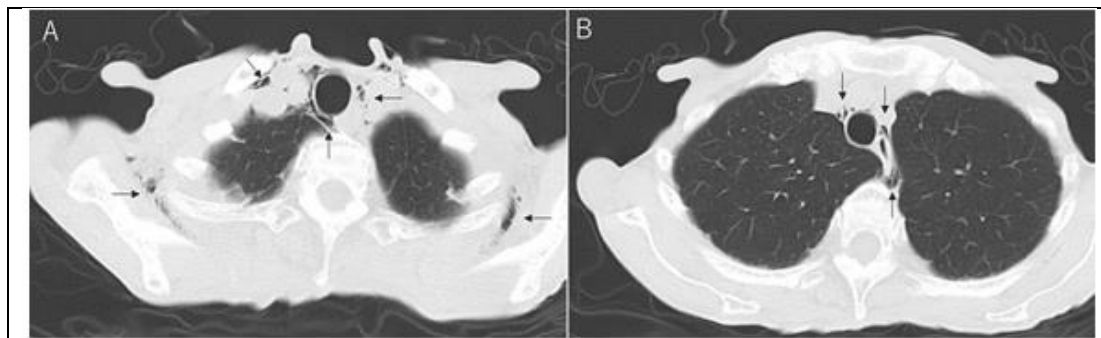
Chest computed tomography (A) The picture around the lung apex shows open air in the mediastinum and subcutaneous emphysema in the back's soft tissues. (B) Free air is visible from the spine to the mediastinum that surrounds the bronchi.
